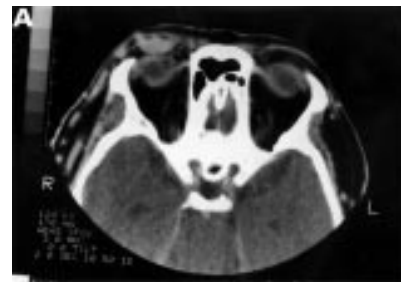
(A) Computed tomographic scan shows a soft tissue homogeneous mass in the right upper eyelid, 2.5 × 1 cm in size, retroseptal, anteriorly placed, separate from lacrimal gland and eyeball, and without any extension in the orbit or cranium. (B) Surgical exposure of arteriovenous malformation via anterior approach shows large sausage-shaped, thick walled, pulsating lesion with several tributaries.
